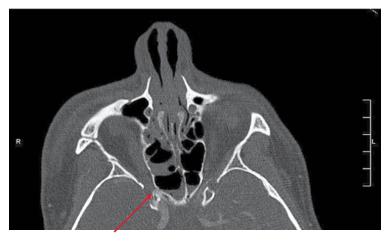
Axial computed tomography scan showing fracture of the right optic canal (red arrow).
